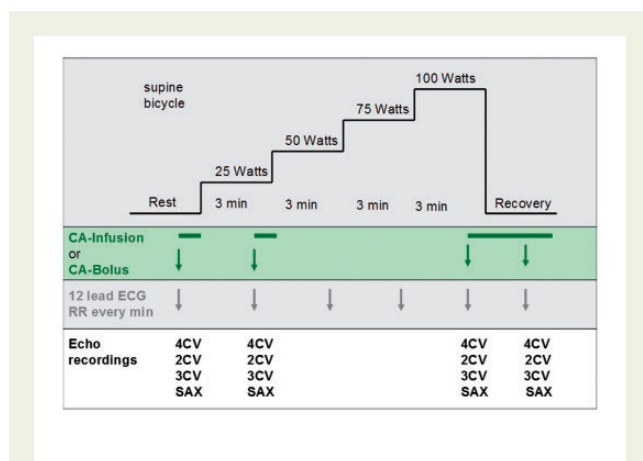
Protocol for supine bicycle stress and using contrast agent (CA) infusion or injections. In this example, the patient was able to exercise at 100 W. The load is increased by 25 W every 3 min. Cessation of exercise according to the EAE consensus for stress echocardiography.²¹⁷ In this example, the patient exercised at maximum effort at 100 W. Additional images may also be acquired at intermediate stress (70% of target heart rate). 4CV, four-chamber view; 2CV, two-chamber view; 3CV, three-chamber view (parasternal long axis view can be used instead); SAX, parasternal short axis view.
